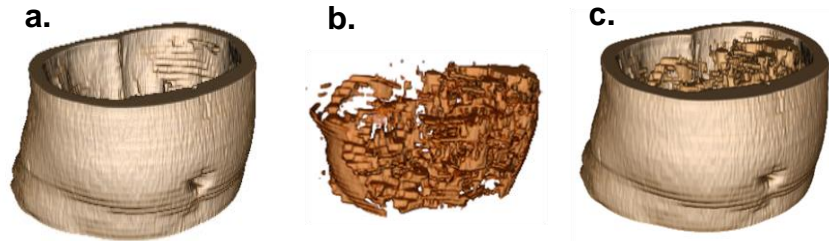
Visualization of volumetric abdominal adiposity reconstructed from all twenty MRI slices. (a) SAT, (b) VAT and (c) Combined SAT and VAT.
